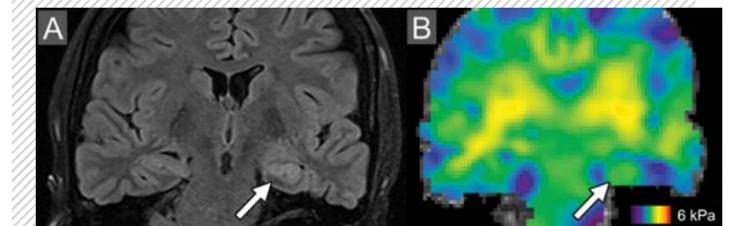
Imaging of the hippocampus in a 29-year-old patient with mesial temporal sclerosis epilepsy. (A) Coronal T₂-FLAIR MRI with arrow highlighting signal hyperintensity in left hippocampus, which is a signature of tissue pathology and the epileptogenic source. (B) Viscoelastic shear stiffness map with the epileptogenic hippocampus highlighted as a clearly stiff region.
